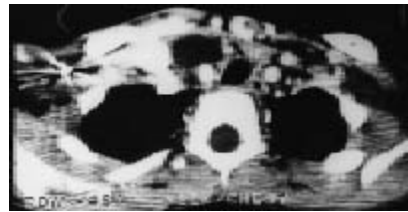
Axial contrast-enhanced CT shows the cyst extending into the superior mediastinum in the right paratracheal region anterior to the innominate artery.
